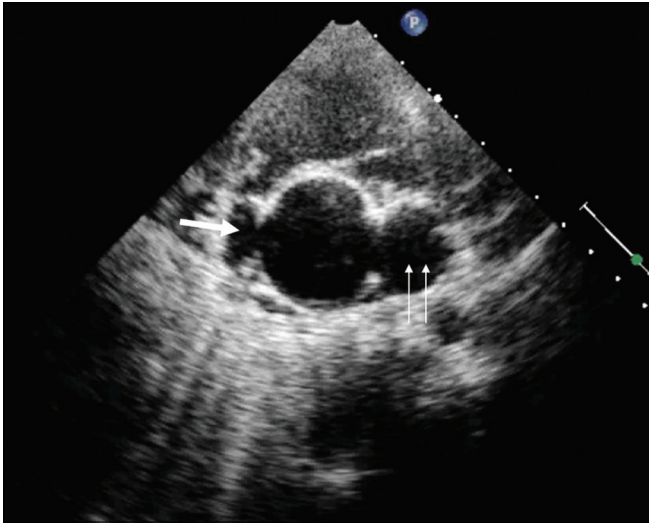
Parasternal short axis view at the level of aortic valve showing dilated left coronary artery (two arrows) and right coronary artery (single arrow)
